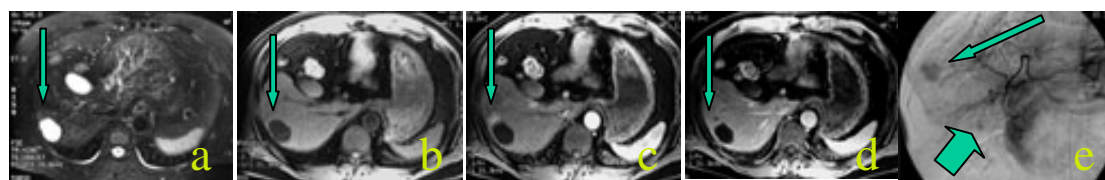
Fig A-51-year old male with pathologically proved two small HCCs (a) T2WI, (b) T1WI* with fat saturation, (c) Gd-DTPA arterial phase, (d) portal venous phase, (e) DSA. The large lesion (arrow) were detected and characterized by the gadolinium-enhanced 3D MR image set. The small lesion (arrowhead) were only detected and characterized by DSA.
